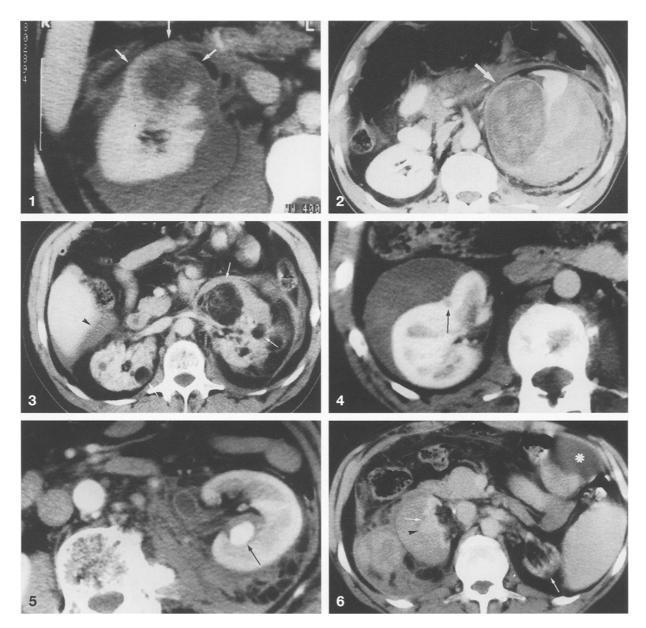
Ruptured renal cell carcinoma with subcapsular and perirenal hemorrhage. Enhanced CT scan demonstrates a ruptured peripherally enhancing mass (*arrows*)
